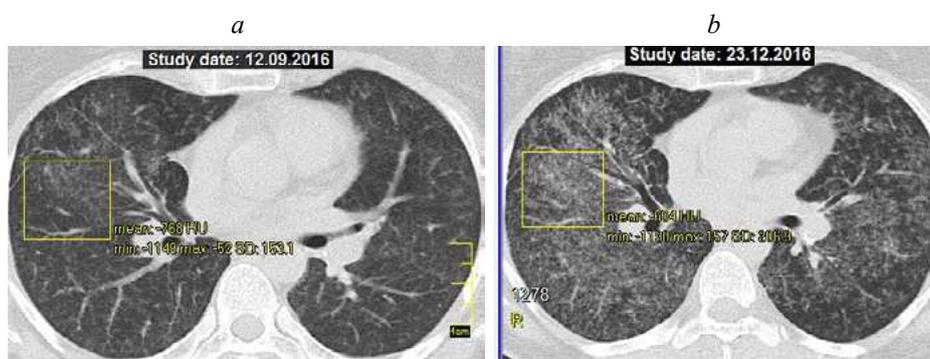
CT of the patient G., sarcoidosis of the lung, stage II: *a* – before the appointment of leflunomide, (densitometry of the parenchyma before treatment – (–768 HU)); *b* – after 3 months of treatment with leflunomide: significant increase in the density of nodular dissemination of the lungs (parenchyma densitometry after 3 months of therapy – (–604 HU))
